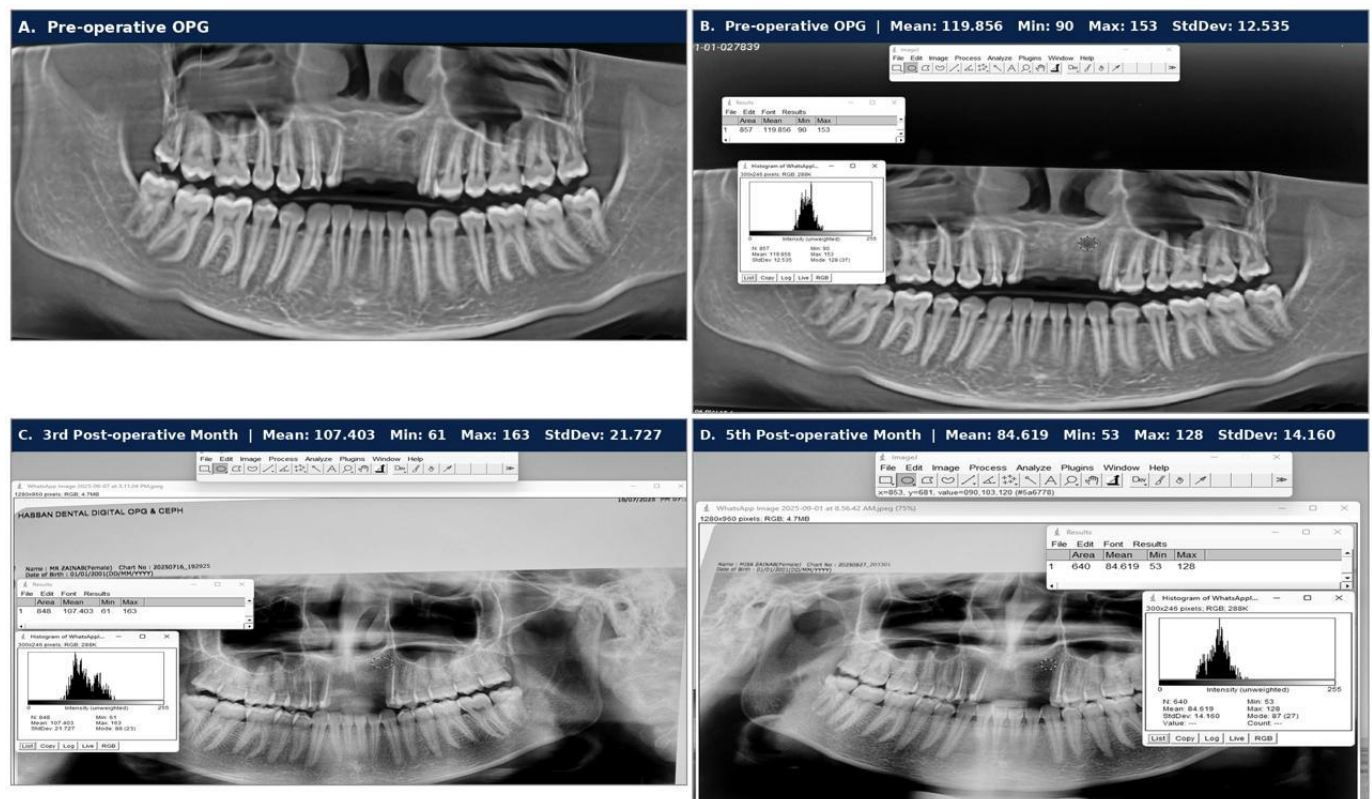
Grayscale orthopantomogram demonstrating progressive osseous regeneration following odontogenic cyst enucleation with Platelet-Rich Fibrin at pre-operative, 3rd and 5th post-operative months.
